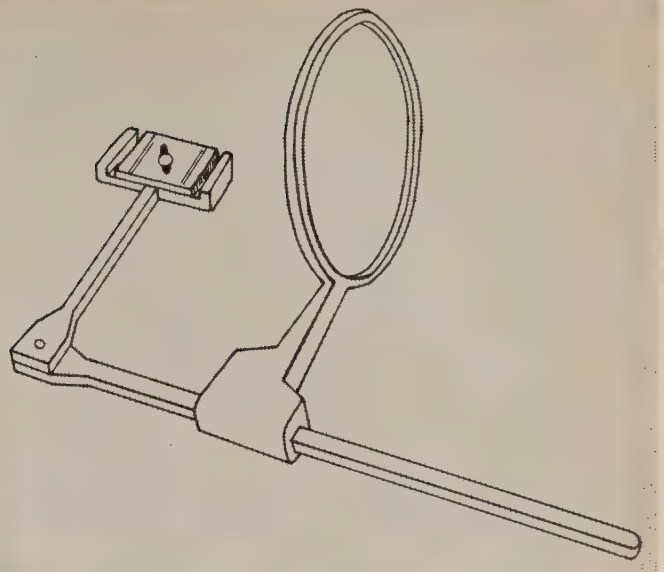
Instrument for posterior teeth used in the long cone paralleling technique. (Updegrave, W.J. New horizons in periapical radiography. Rinn Corporation.)
